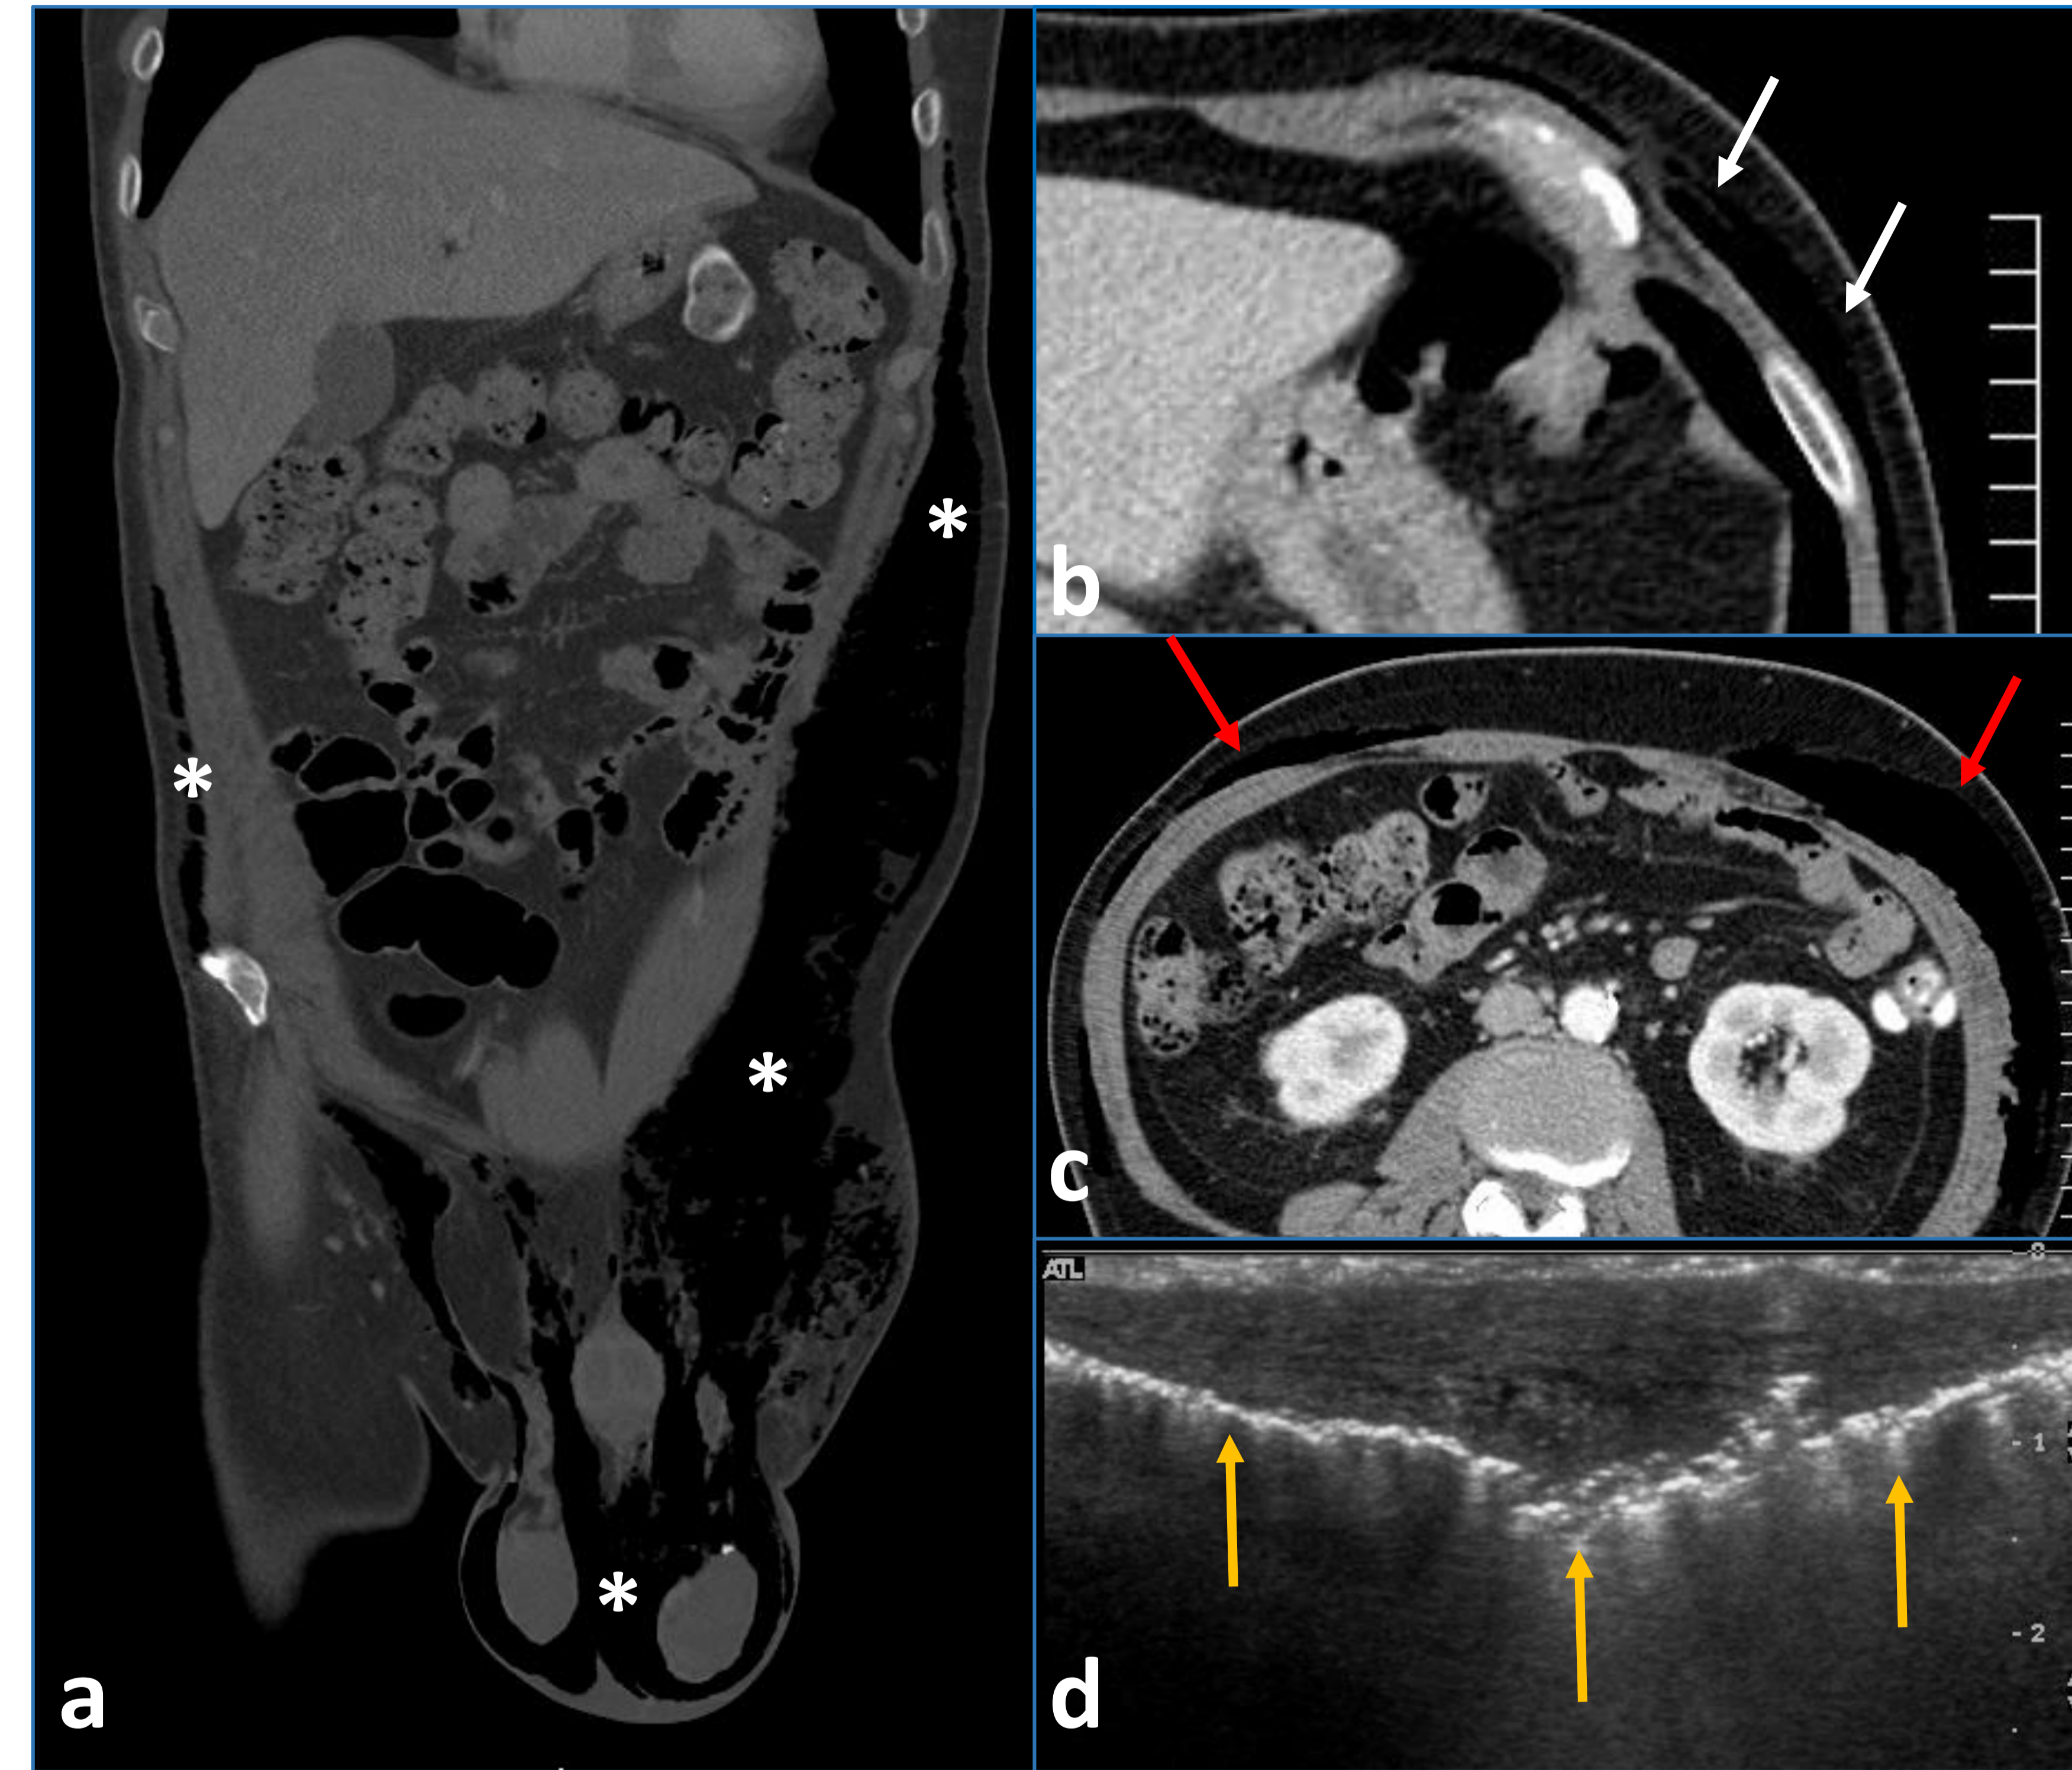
Fournier's gangrene with extensive spread to chest wall. a coronal CT image shows extensive spread of soft tissue gas involving scrotum, inguinal area, perineum, anterior abdominal wall up to left anterior chest wall (*). b, c axial CT images demonstrate soft tissue gas along left anterior chest wall (arrow) and abdominal wall (red arrow). d US image at left inguinal area shows soft tissue edema with extensive soft tissue gas (yellow arrow).
